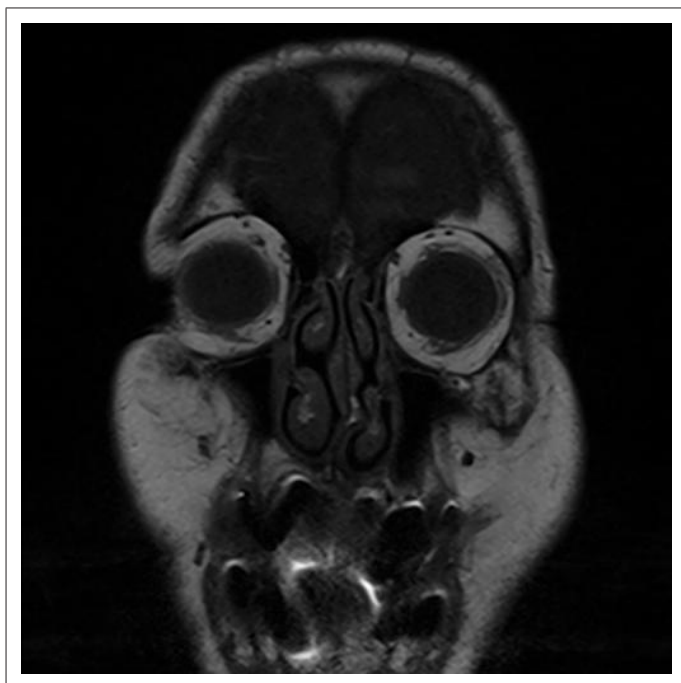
Bilateral choroidal effusions were no longer visible on magnetic resonance imaging after treatment.
